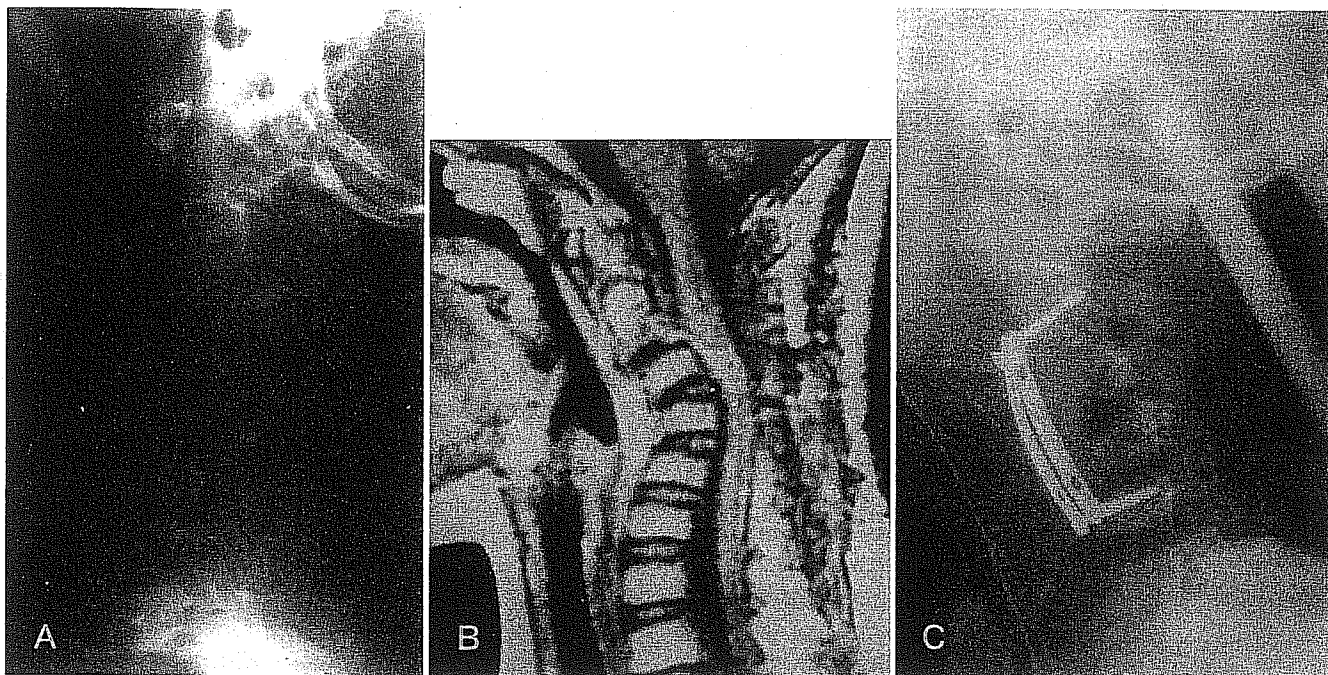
(A) Lateral cervical spine x-ray of an 8-year-old boy who underwent decompressive laminectomy at the C2–C4 level for a compressive extradural granuloma. The kyphotic deformity is most severe at the C3–C4 level. (B) Sagittal magnetic resonance image (MRI) shows spinal cord compression from the kyphosis, which is
